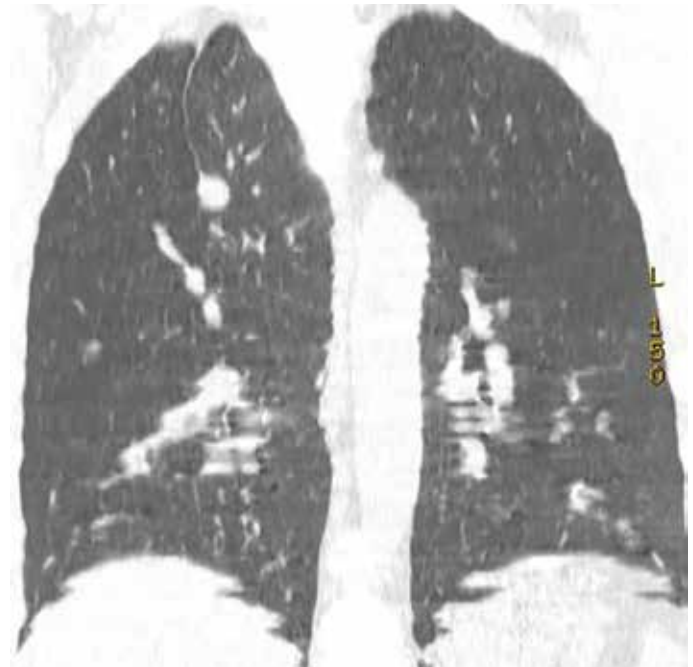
Computed tomography coronal image
